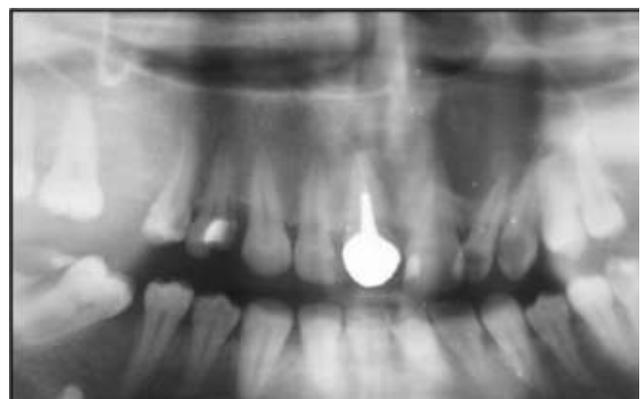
Panoramic radiograph of a radicular cyst in the upper jaw (left)
